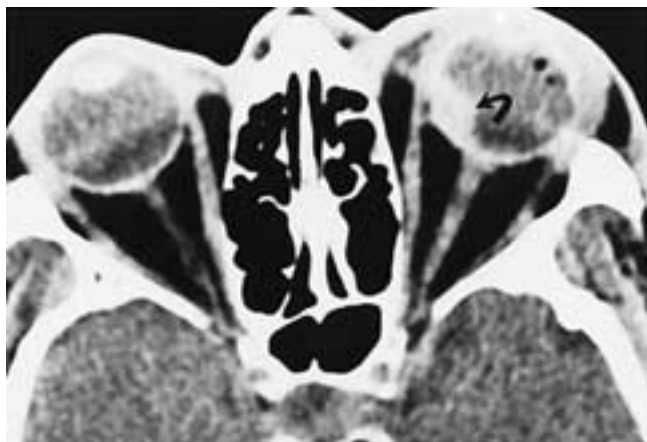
Acute choroidal hematoma. Axial CT scan shows a hyperdense mass (*arrow*) related to traumatic choroidal hematoma. Note the air bubbles in the left globe.
